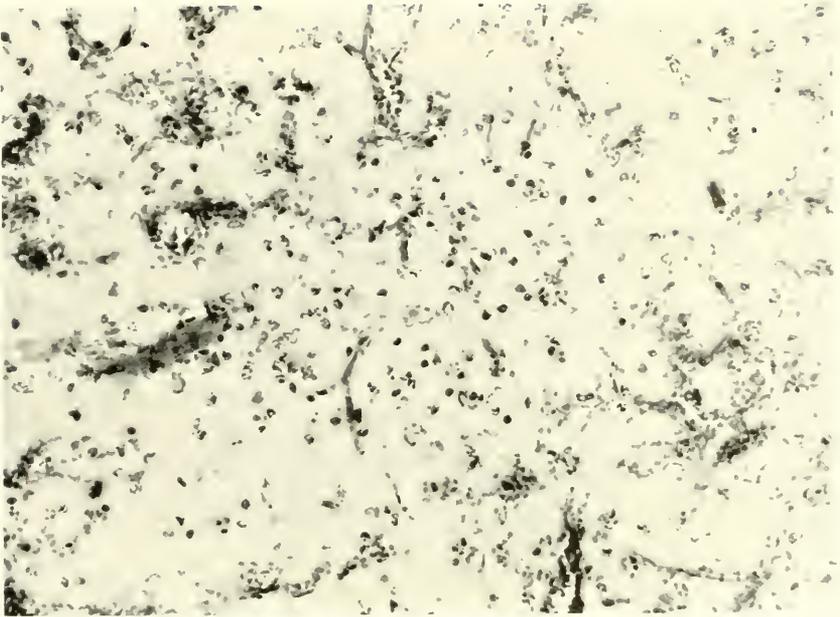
Multiple hemorrhages, pyknosis, and rhexis of tissue cells and of emigrated polymorphonuclear leucocytes in a necrotic region of the same type as in FIG. 8 and produced by the same x-ray dose. H. and E.
